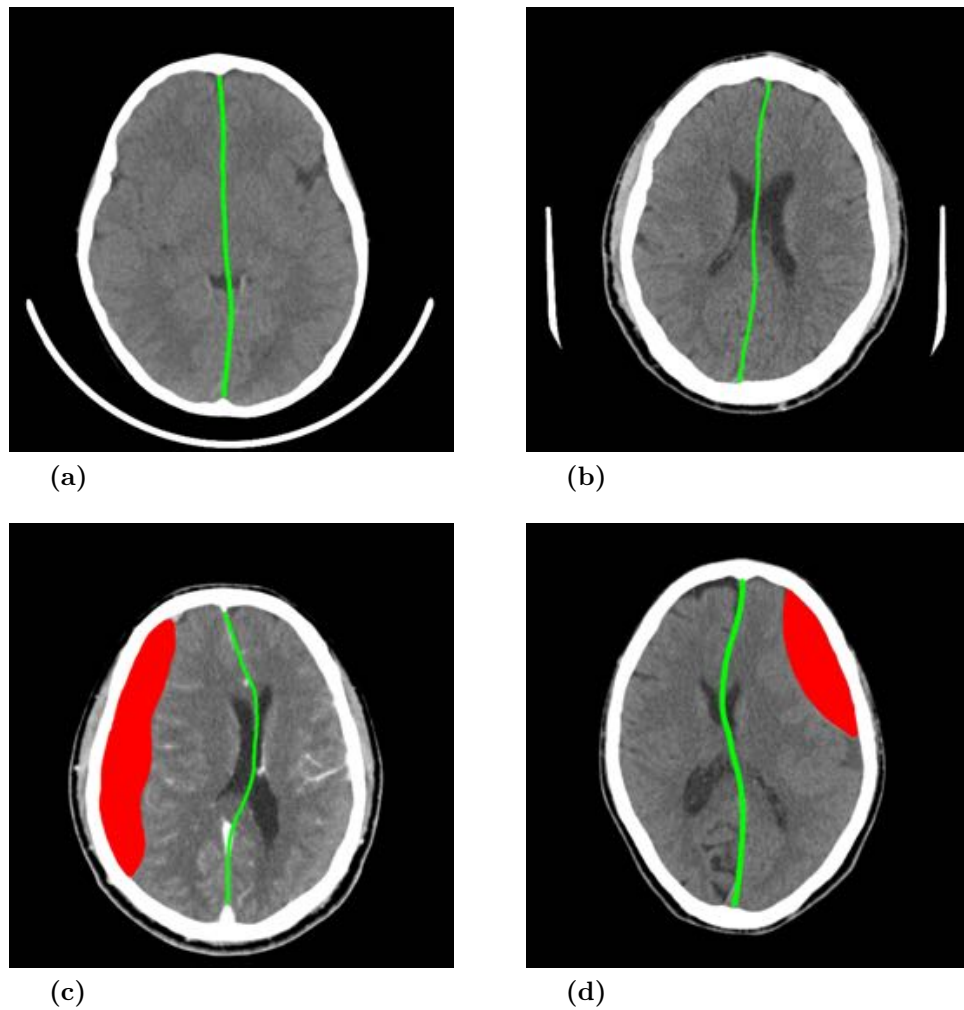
Manual annotation of the midline (green) on brain CT scans. Images (a) and (b) shows the midline with no shift. Image (c) has haematoma on the right side and the midline is shifted towards left (of patient) on the CT. Image (d) has haematoma on the left side and the midline is shifted towards right of the patient.
